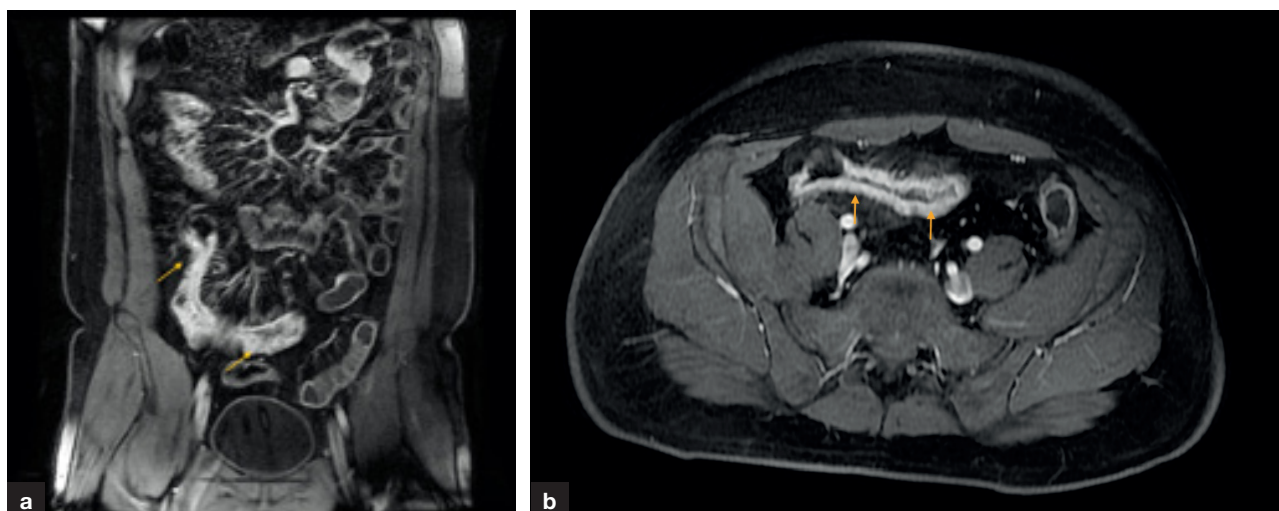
a. Coronal and (b) axial magnetic resonance images (post contrast) demonstrating marked mucosal hyperenhancement of the distal ileum and enhancing mesenteric hypervascularity ('comb sign') in a patient with inflammatory Crohn's disease (arrowed).
